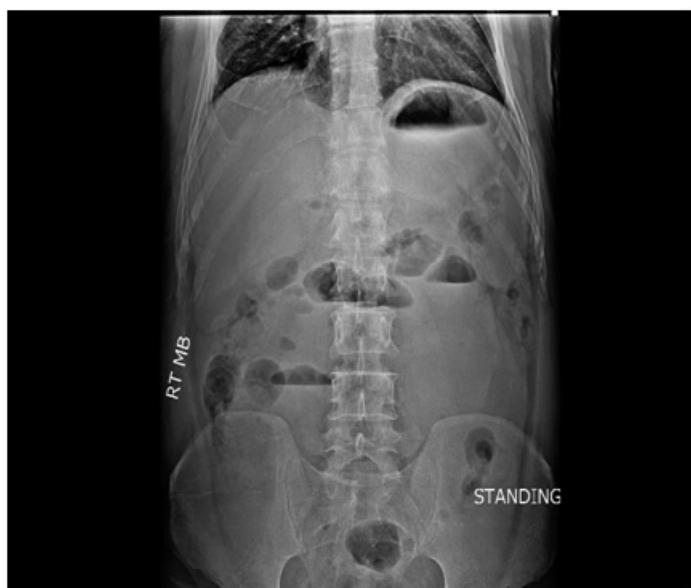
Standing abdominal-pelvic x-ray showing multiple air-fluid levels.
